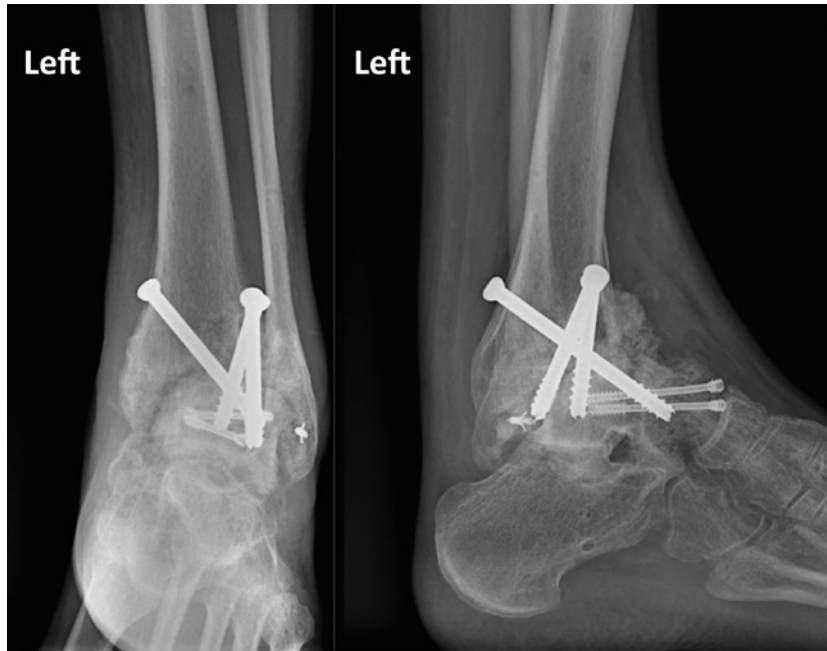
Radiograph after tibiotalar arthrodesis with fresh tibiotalar allograft of the left ankle.
